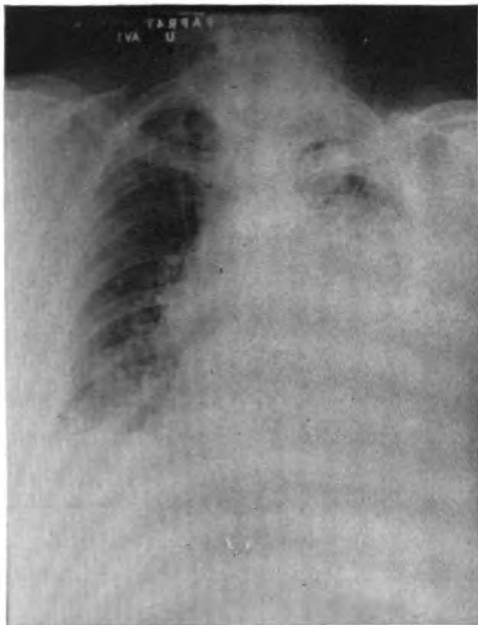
Case 2. Roentgenogram taken prior to treatment. This reveals a homogeneous opacity in the lower two-thirds of the left hemithorax which is interpreted as a pleural effusion.
